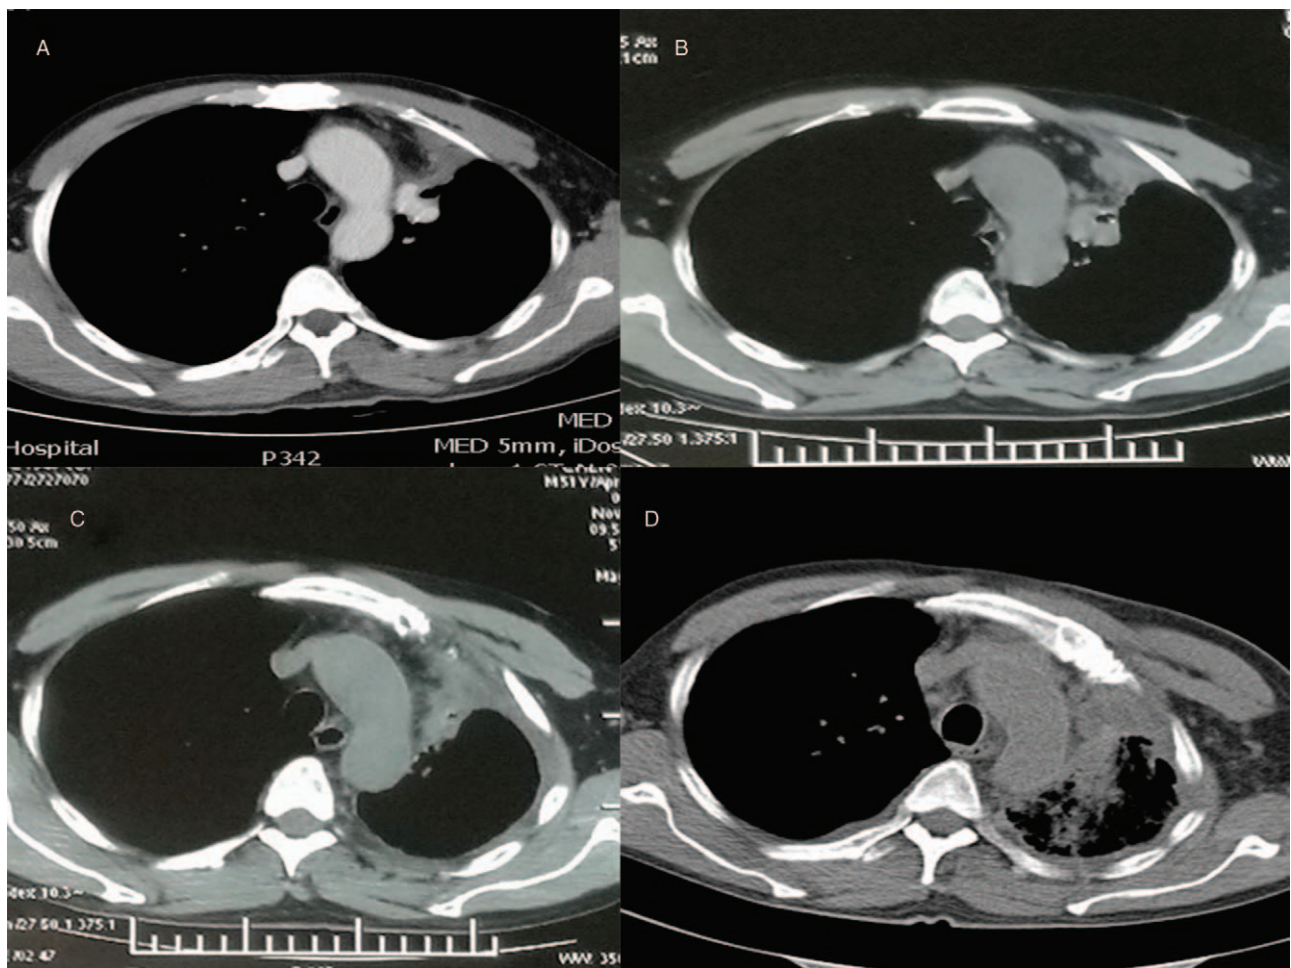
Chest CT. (A) shows SD after 4 cycles of chemotherapy on December 15, 2016. (B) shows multiple pleural metastases on May 31, 2017. (C) shows SD after 5 months cabozantinib on November 9, 2017. (D) shows disease progression after 9 months cabozantinib in March 2017.
